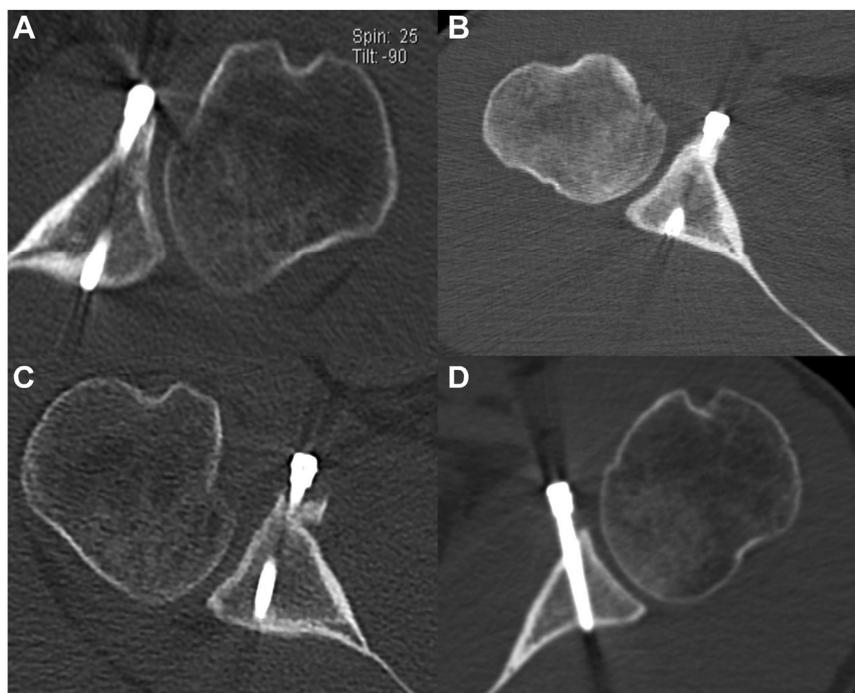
Graft resorption was assessed on the axial computed tomographic images using a modification of the Zhu classification for coracoid graft resorption. (A) Grade 0: no resorption of the graft. (B) Grade I: Exposure of the top-hat washer corresponding roughly to <25% graft resorption. (C) Grade II: Exposure of half the screw shaft length within the graft, corresponding to roughly <50% graft resorption. (D) Grade III: 50% of the screw shaft length within the graft was exposed, corresponding to $\geq 50\%$ graft resorption.
